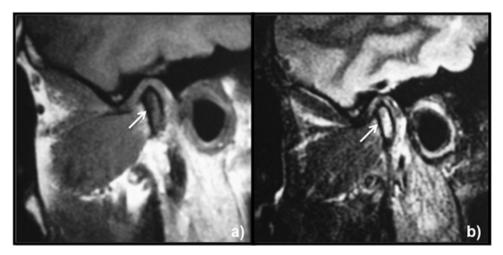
Sagittal view with mouth closed: (a) T1-weighted – an extensive hypointense area in the mandibular condyle (arrow) can be observed; (b) T2-weighted – an area with hyper-signal in the mandibular condyle (arrow) is present, characterizing the presence of bone oedema.
